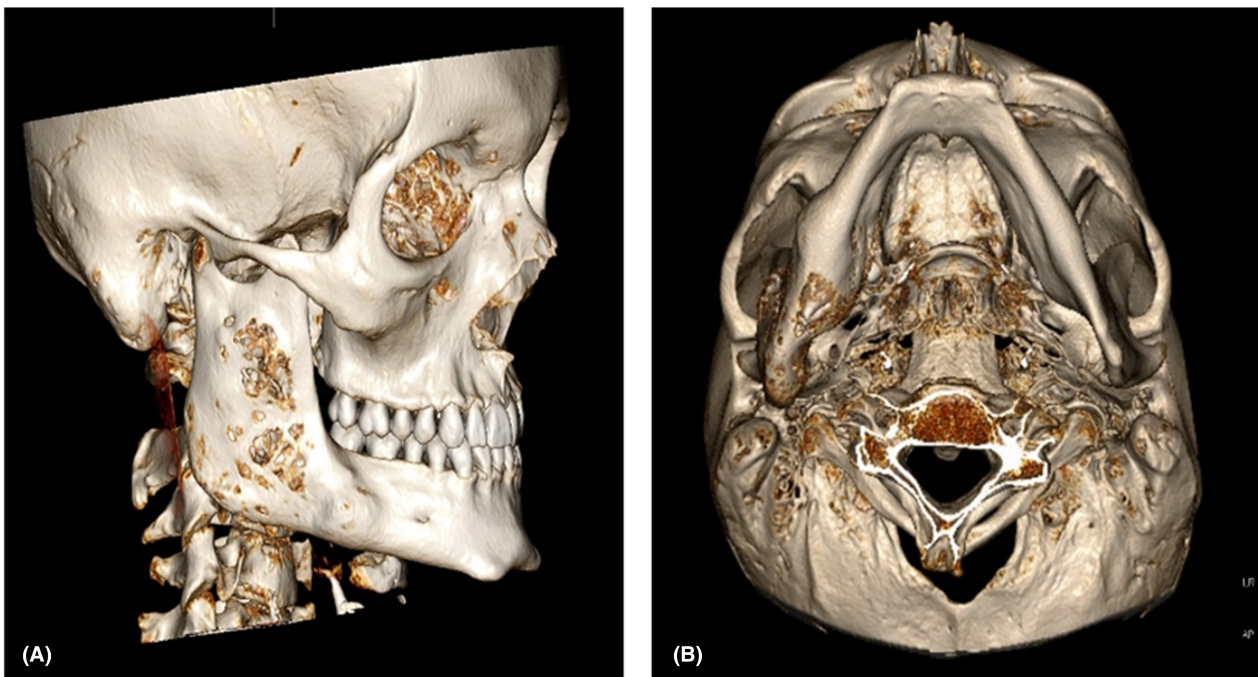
(A) Sagittal and (B) axial 3D reconstructions of the facial bones derived from the CT scan showing cortical expansion and breach. Taken at the initial assessment.
